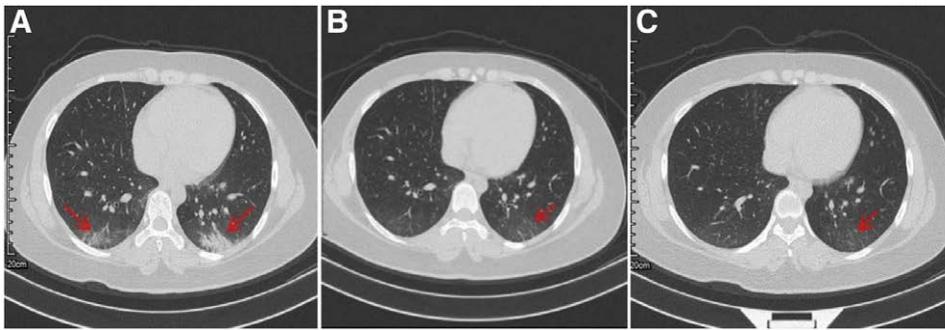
Changes in chest CT images of a female 15 years old infected with 2019-nCoV. A: On admission, much patchy ground-glass opacity in the lung periphery. B: Four days after treatment, some ground-glass shadow but significantly less than in (A). C: Seven days after treatment, some ground-glass shadow and nearly the same as in (B).
